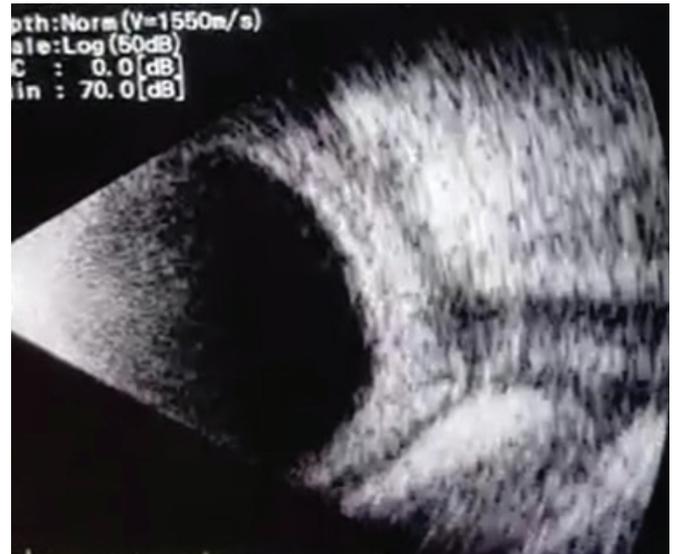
T-sign in B-scan ultrasonography at first visit.
